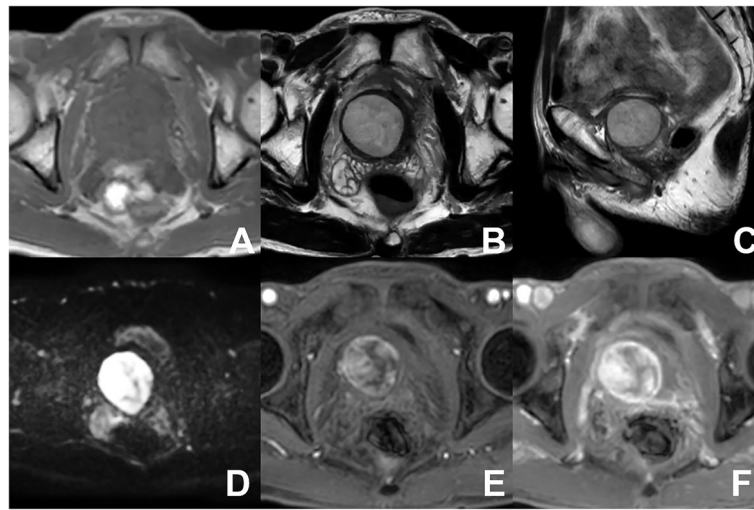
Preoperative magnetic resonance scan. A T1-weighted imaging revealed irregular enlargement of the prostate. B, C T2-weighted images revealed a well-margined, oval, hyperintense lesion with a hypointense rim located in right basal part of the prostate, measuring approximately 3.3 cm by 3.2 cm. D Diffusion-enhanced imaging revealed the lesion was hyperintense. E, F Dynamic contrast-enhanced magnetic resonance imaging revealed that the lesion exhibited significant peripheral enhancement.
